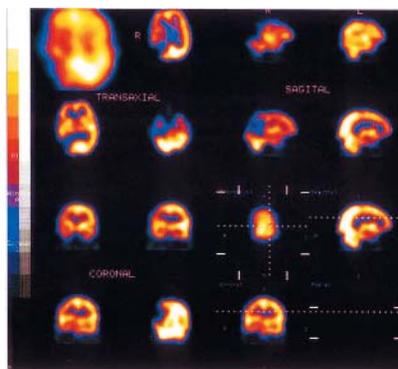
SPECT scan shows perfusion defects in the right parietal, occipital, and temporal area.
